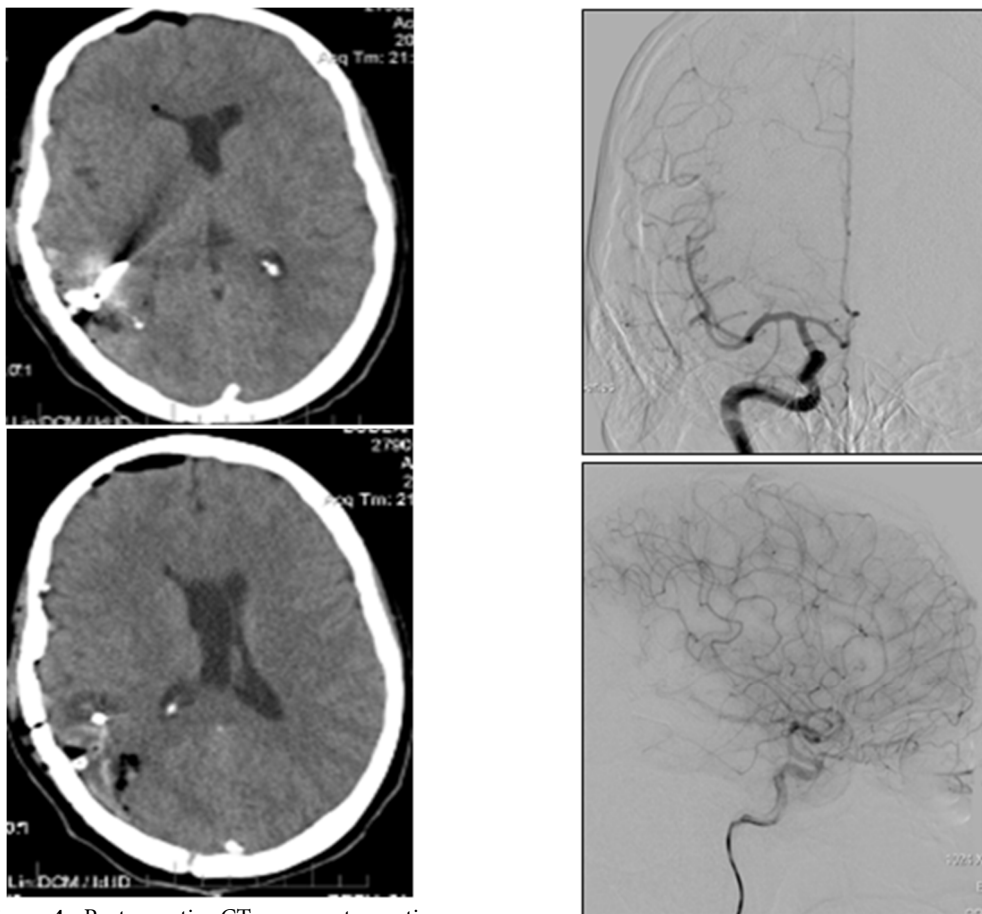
Postoperative CT scan, postoperative aspects, titanium clips
